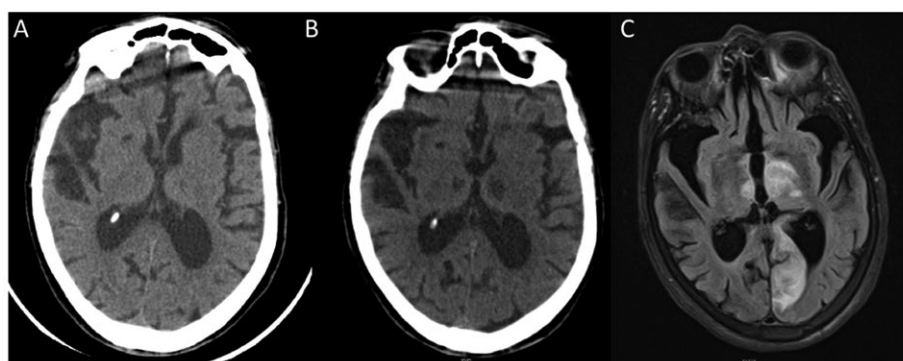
Brain imaging across time. A) Head computed tomography (CT) scan at admission showing no acute intracranial pathology documenting previous right lacunar infarct and microvascular ischemic disease (figure 2a). B) CT at 48 hours after admission demonstrating hypodensities visible on both thalami, more evident on the left side extending to mesencephalic region. C) T2-weighted brain MRI at 24 hours after admission picturing subacute bilateral infarcts affecting both thalami and mesencephalon most evident on the left along with subacute infarct affecting the territory of left posterior cerebral artery with evidence of hemorrhagic transformation.
